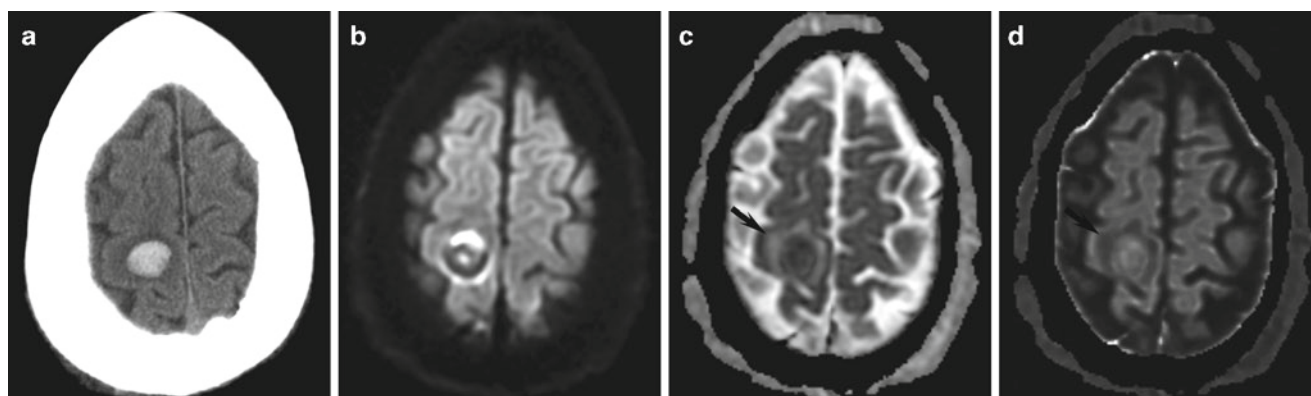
Diffusion abnormalities associated with acute hemorrhage. (a) Axial unenhanced CT demonstrates an acute right superior frontal subcortical hematoma. (b) Axial DWI, (c) ADC, and (d) exponential MR images demonstrate predominantly restricted diffusion, consistent
